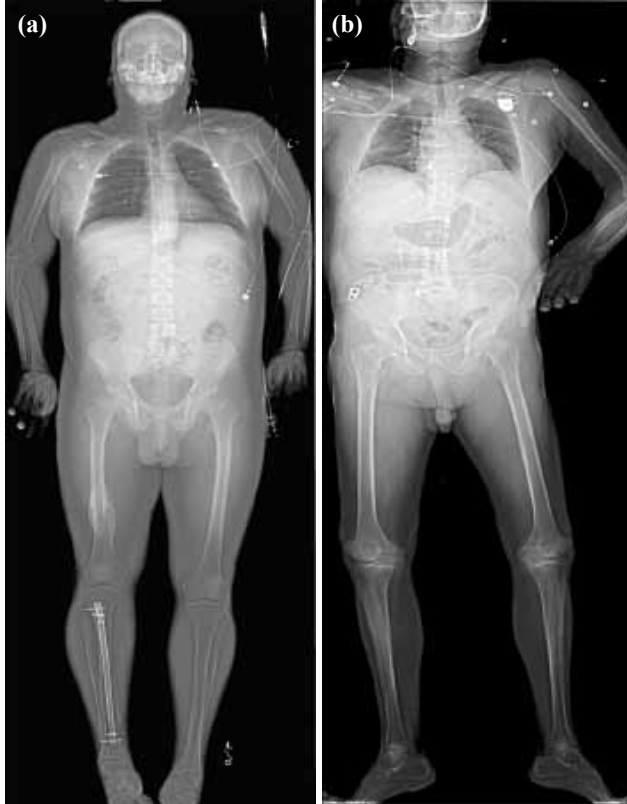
Hardware incidentally found on Lodox[®] scanning. Two patients presented to the trauma bay following head injury. (a) A 43-year-old male who fell off his roof was found to have a right tibial orthopedic rod. (b) A 63-year-old female who fell in the shower was found to have a pacemaker. The identification of metallic hardware in unresponsive patients is important in directing the choice of further imaging studies (ex: computed tomography versus magnetic resonance imaging), revealing clues to medical history (ex: pacemaker, aneurysm clips), as well as guiding the need for further assessment. These cases demonstrate the advantage of screening all trauma patients with whole-body Statscan[®] imaging.
